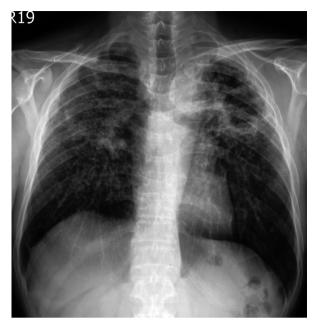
Chest radiograph (PA view) showing baseline LUL cavity with pneumoconiosis background, taken 3 months before the patient visited our outpatient clinic.
